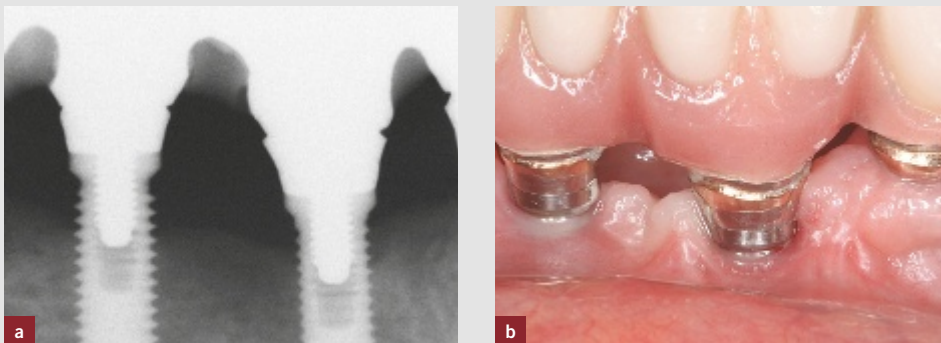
Implants where there has been loss of supporting tissue: (a) radiograph, (b) the exposure of the implant head in the mouth.
